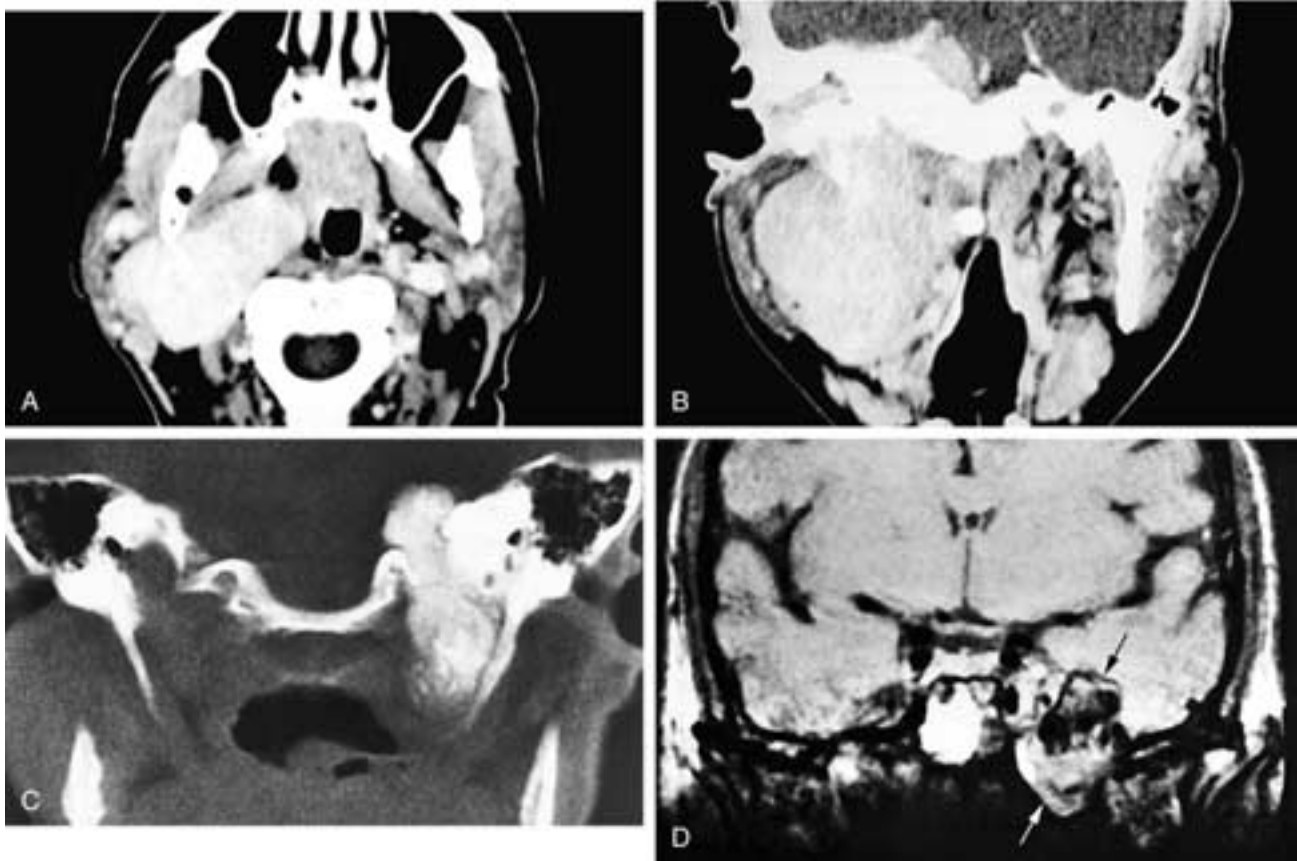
Axial (A) and coronal (B) contrast-enhanced CT scans show a homogeneously enhancing mass in the right parapharyngeal space, the right skull base (which is thickened and sclerotic), and the right posterior fossa. This is a fairly typical imaging appearance for a meningioma. Coronal CT scan (C) shows a heavily calcified meningioma extending from the left posterior fossa down into the left parapharyngeal space via the jugular fossa. Coronal T1-weighted MR image (D) shows a nonhomogeneous giant aneurysm in the left middle cranial fossa (black arrow) that extends down into the left parapharyngeal space (white arrow).
